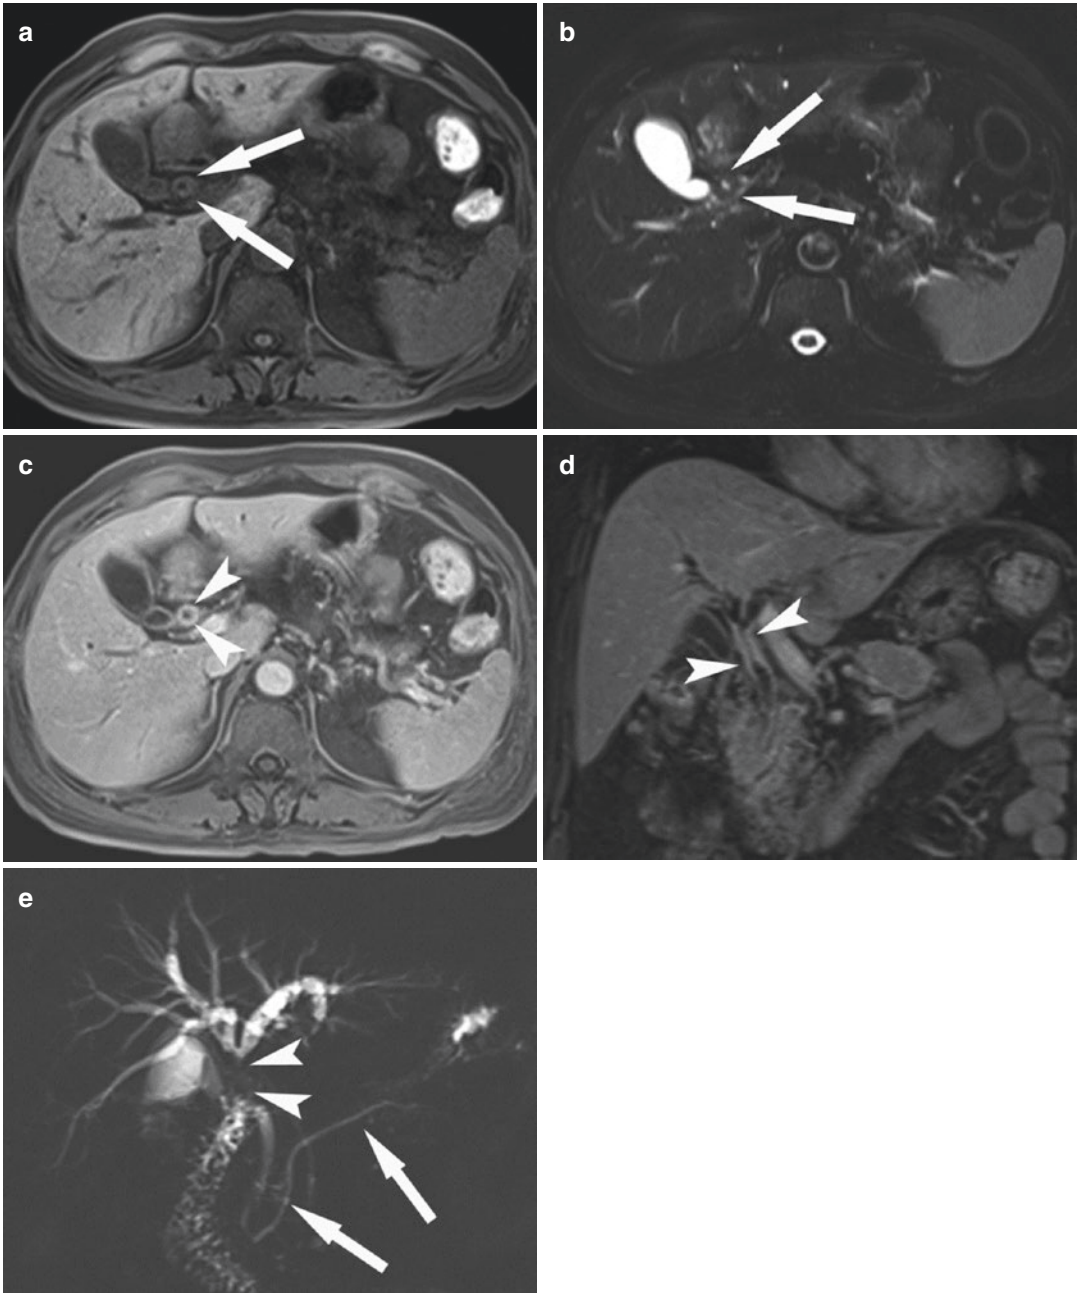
IgG4-related sclerosing cholangitis. (a) T1-weighted axial image shows a concentric thickened wall of the proximal common ducts with hypointensity (arrows) in comparison with the hepatic parenchyma. (b) T2-weighted axial image shows a homogeneously isointense thickened wall of the proximal common ducts (arrows) in comparison with the hepatic parenchyma. (c, d) Contrast-enhanced axial (c) and coronal (d) images show a segmental thickened wall of the proximal common
